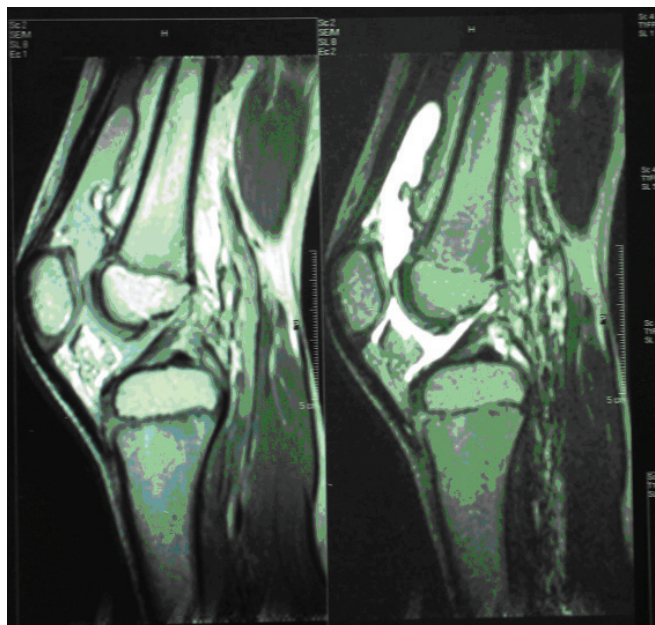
MRI of left knee, showing synovial hypertrophy with indentations and fat signal intensity in supra-patellar area.
